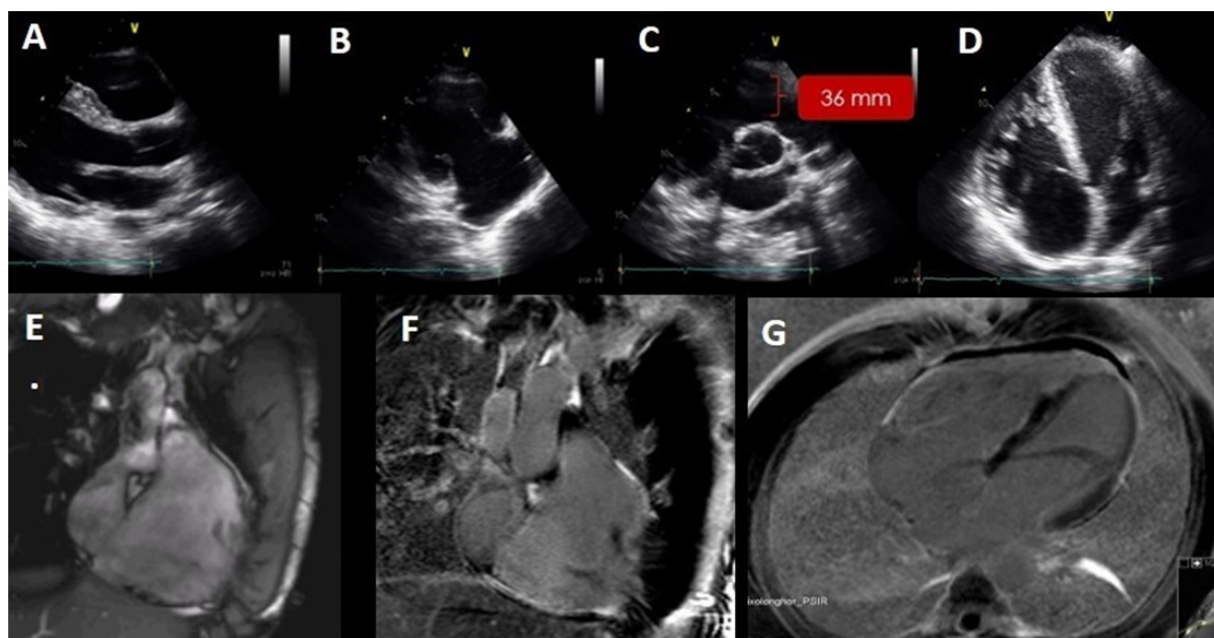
Top: TTE with dilated right chambers (A: parasternal view; B: right chambers parasternal view; C: short axis view showing RV outflow tract), hypertrabecular RV (D: four-chamber view) and biventricular systolic dysfunction. Bottom: CMR revealed LV end-diastolic volume in the upper limit of normality with mild systolic dysfunction, severe RV dilatation, dyskinesia in outflow tract and severe RV systolic dysfunction (E). Late gadolinium enhancement was visible in the RV outflow tract (transmural) and in the LV inferolateral wall (subepicardial) (F and G). TTE: transthoracic echocardiography; CMR: cardiac magnetic resonance; RV: right ventricle; LV: left ventricle.
